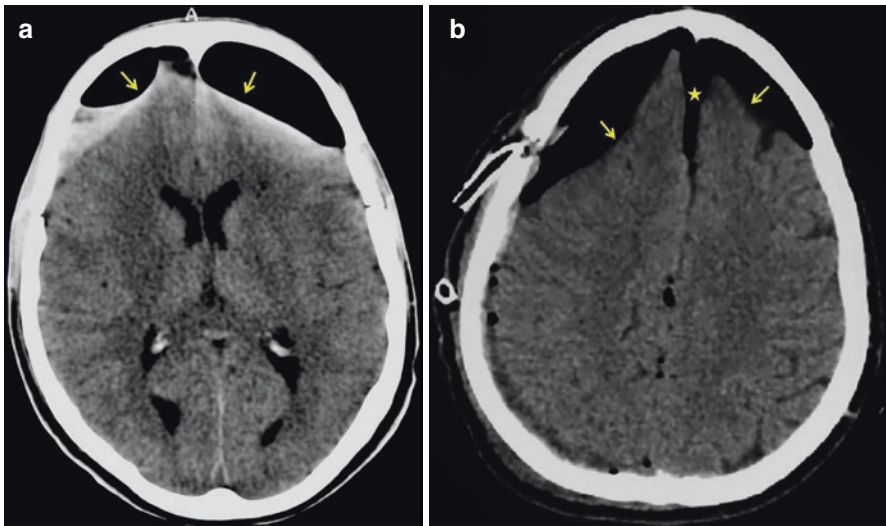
Postoperative cranial axial CT scan in two different patients (a, b) with bilateral compressive pneumocephalus (arrows) following burr holes surgery for bilateral chronic SDH. Note the frontal interhemispheric pneumocephalus (star) and the “Mount Fuji sign”
